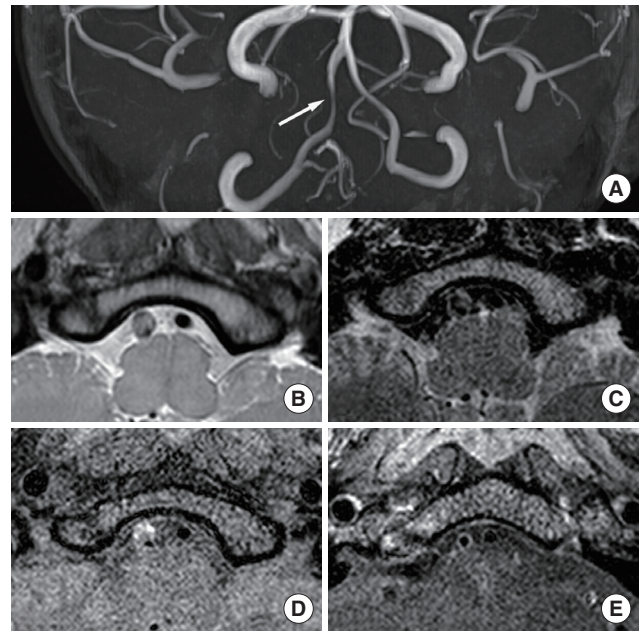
Intracranial artery dissection. A 37-year-old female patient presented with dizziness. (A) Time-of-flight magnetic resonance angiograph showing severe stenosis in the right vertebral artery (arrow). (B) Intramural hematoma and aneurysmal dilatation on proton-density imaging. (C) Intramural hematoma presenting as hyperintensity and hypointensity on T2-weighted imaging, and (D) intramural hematoma presenting as hyperintensity and isointensity on T1-weighted imaging. (E) Artery distal to the dissected segment showing periarterial enhancement on contrast-enhanced T1-weighted imaging.
